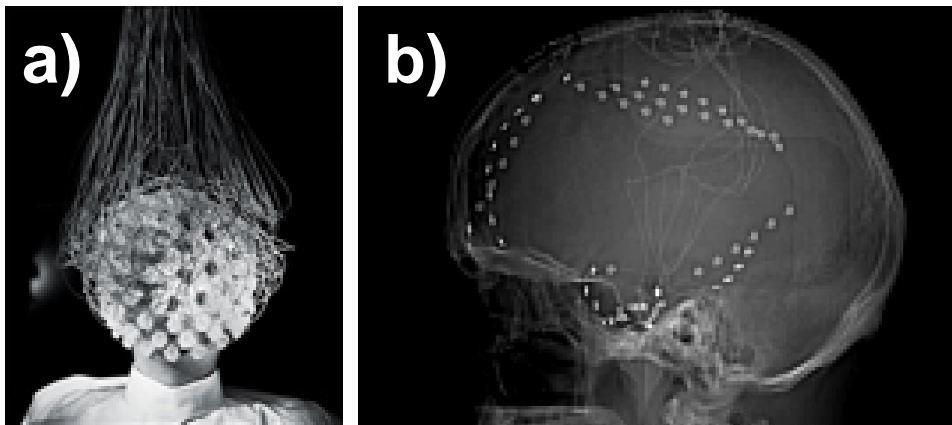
Simultaneous recording of EEG and ECoG: (a) Example of EEG electrode placement. (b) Sagittal X-ray of our subject’s ECoG electrode placement.
